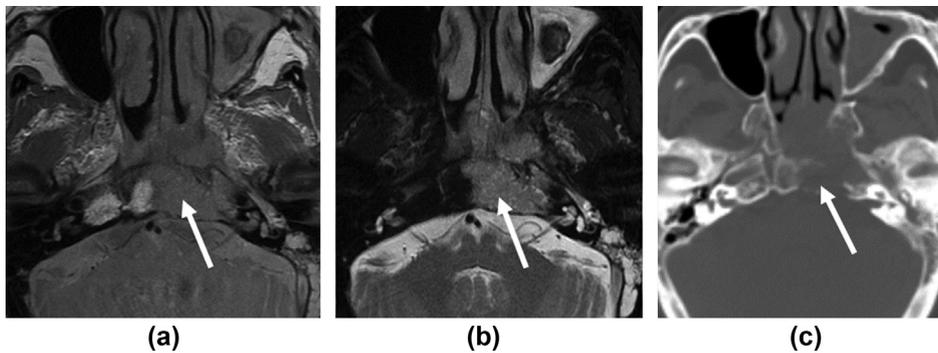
Skull base involvement of the NPC seen as loss of normal fatty marrow on Axial T1 and T2-weighted images (arrow in A and B) at clivus and bone erosion on Axial CT image (arrow in C).
